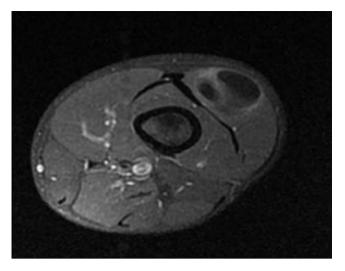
Frontal view of MRI with T2 weighted images showing cystic mass in the left vastus lateralis muscle. The enlargement of the mass is approximately  $77 \times 20 \times 18$  mm.
